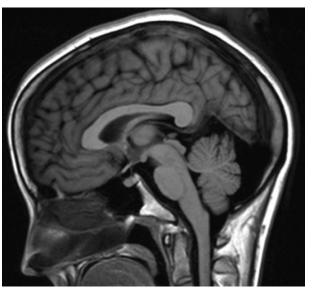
Magnetic resonance imaging findings for case 1. Sagittal T1-weighted sequence demonstrating that the brainstem and cerebellar vermis have normal appearances. An arachnoid cyst is incidentally seen in the posterior fossa.
